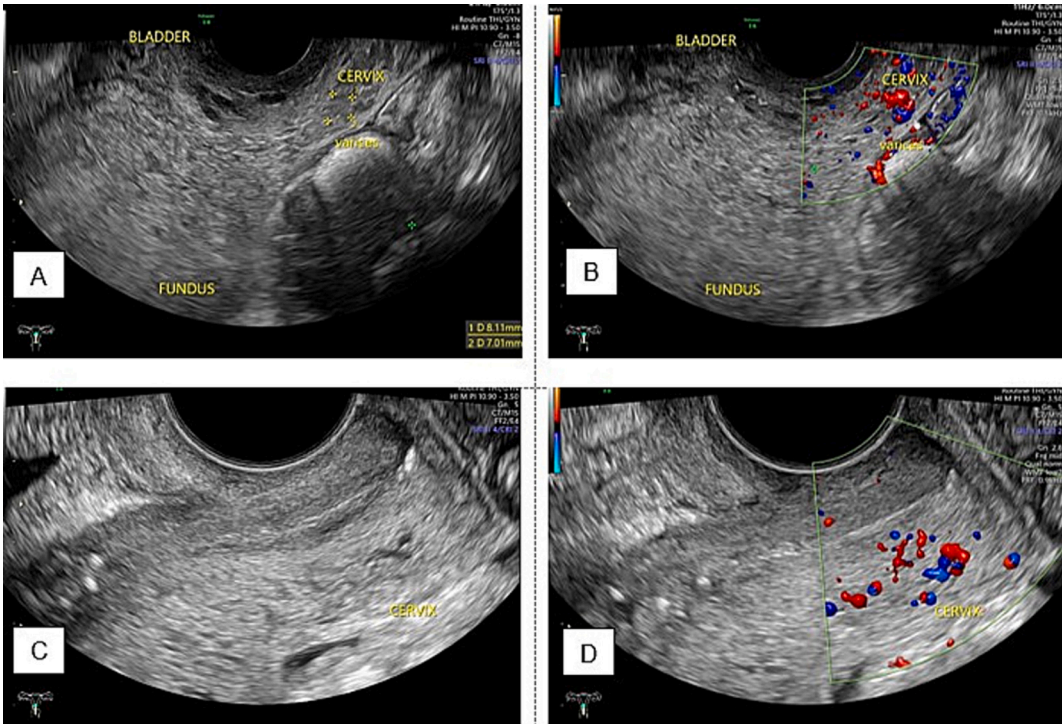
A and B: Transvaginal ultrasonography of the cervical varix on postoperative day 10. C and D: Transvaginal ultrasonography of the cervical varix on postoperative day 43.
